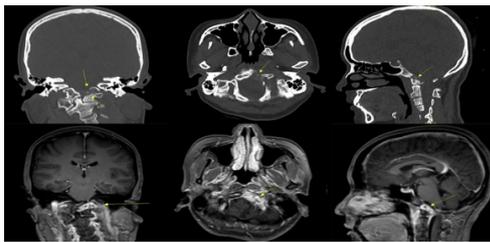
Contrast enhanced brain MRI bone window (row 1) and T1W (row 2) revealing reduction of soft tissue inflammation, destruction of the clivus and left C1 vertebral body upon 1 year follow-up
